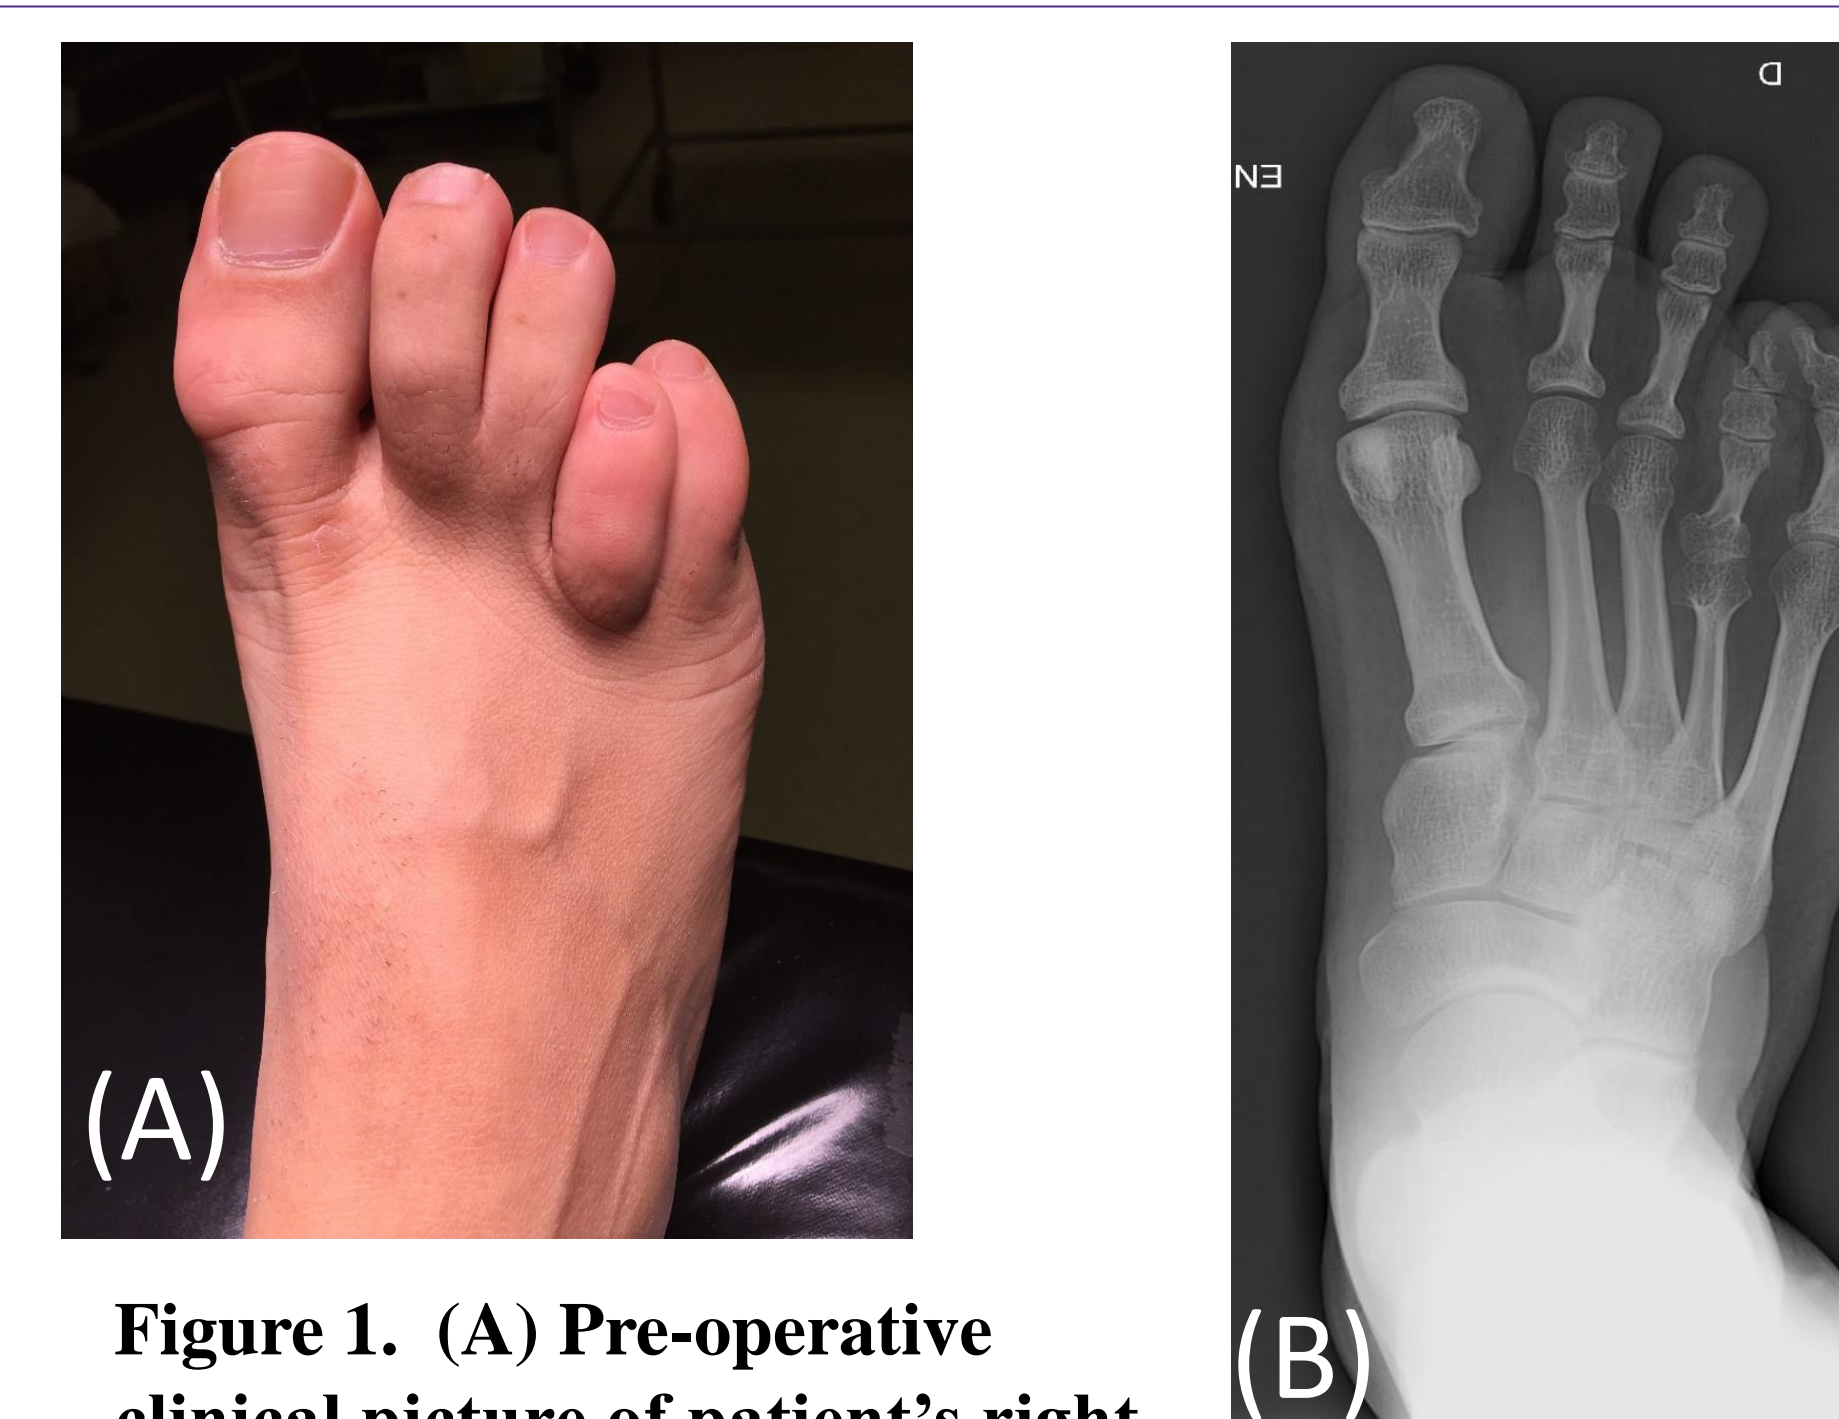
(A) Pre-operative clinical picture of patient's right foot (B) Pre-operative AP radiograph of patient's right foot.
